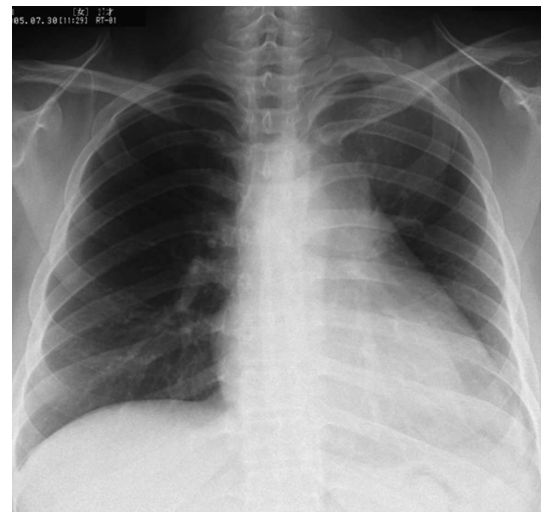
Chest X-ray shows mild cardiomegaly.
